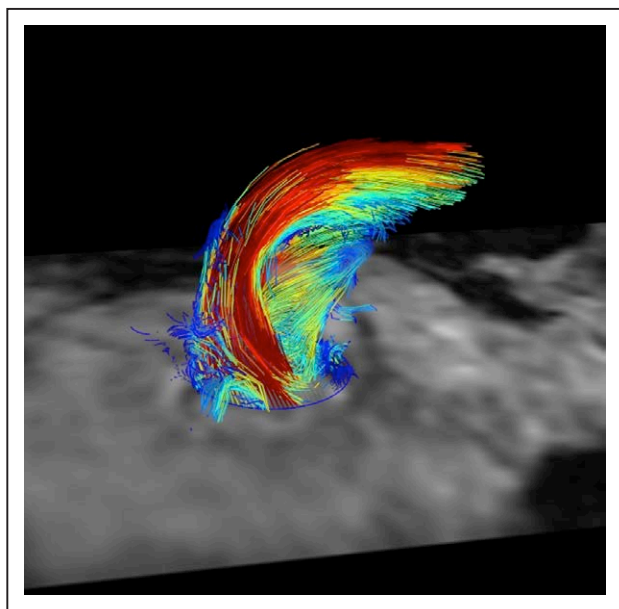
Representative examples of systolic 3-dimensional velocity fields in the ascending aorta obtained by 4-dimensional flow magnetic resonance imaging in a patient with severe aortic stenosis.
